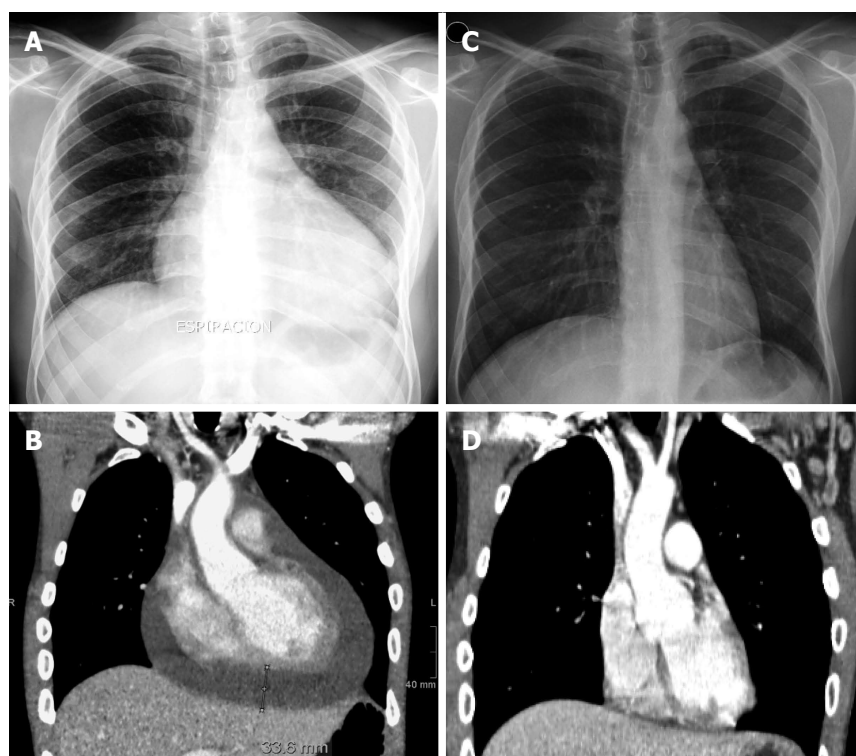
Radiograph of the chest and computed tomography scan before and after mesalazine suspension. A: Chest radiograph showing an enlarged cardiac silhouette due to a cardiac effusion during mesalazine treatment; B: Computed tomography (CT) scan of the chest revealing cardiomegaly due to a large pericardial effusion (maximum width of 33.6 mm) during mesalazine therapy; C: Normal chest radiograph after mesalazine withdrawal; D: CT scan of the chest showing a complete resolution of the pericardial effusion after suspension of mesalazine.
